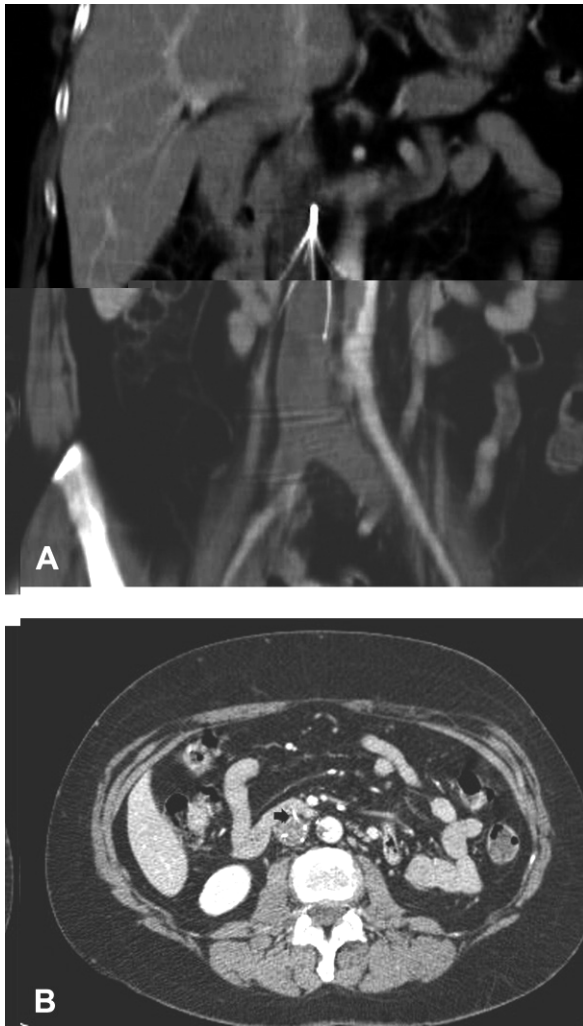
A, Computed tomography angiography of the abdomen demonstrated the complete thrombosis of the inferior vena cava, just above the renal veins, which were not involved by thrombosis. The filter's hooks perforated the inferior vena cava wall and aorta, in which a mural thrombus is clearly evident. B, Computed tomography axial view showed the perforation of duodenum by the filter's hook (*arrow*). Note the partial thrombosis of aortic lumen.
